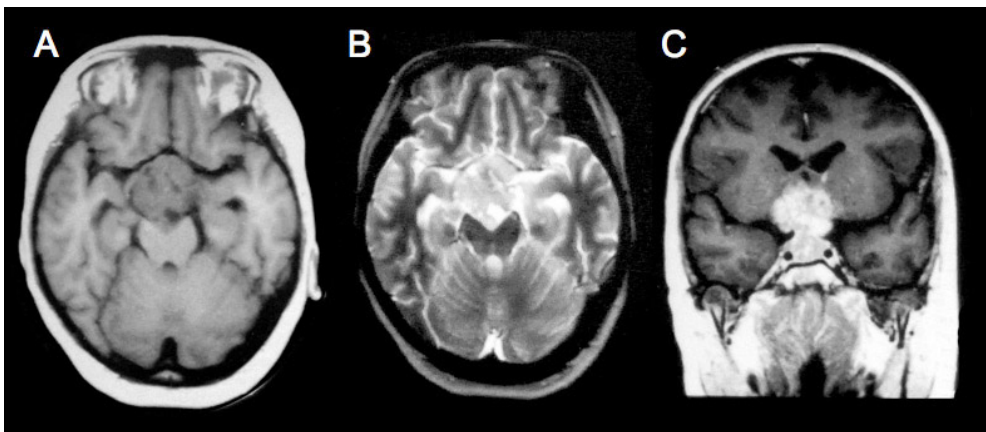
Neurohypophyseal germinoma in a 12-year-old girl. A large tumor is evident in the basal cistern. The tumor shows slightly low signal intensity on the T1-weighted image (A) and slightly high signal intensity on the T2-weighted image (B). A coronal image after enhancement shows that the tumor is well enhanced.
